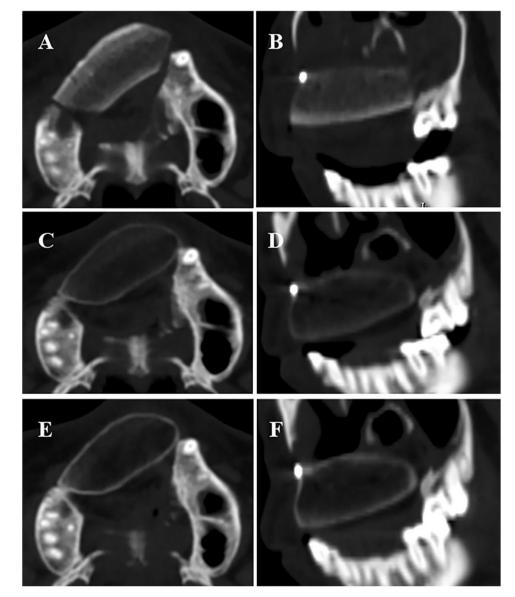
CT images showing changes in the iliac bone of the vascularized free iliac flap after maxillary reconstruction in a male patient aged 36 years. A and B: 1 week after the surgery; C and D: 6 months after the surgery; E and F: 1 year after the surgery.
